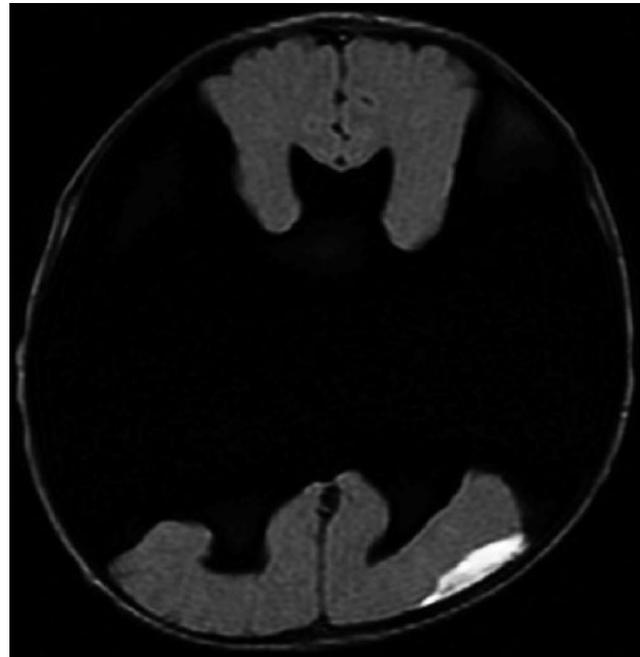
Axial T1-weighted magnetic resonance image of a newborn with hydrocephalus caused by bilateral, severe schizencephaly. Schizencephaly is a neuronal migration disorder similar to holoprosencephaly and other congenital central nervous system malformations, but the genetics of this entity have yet to be elucidated completely.
